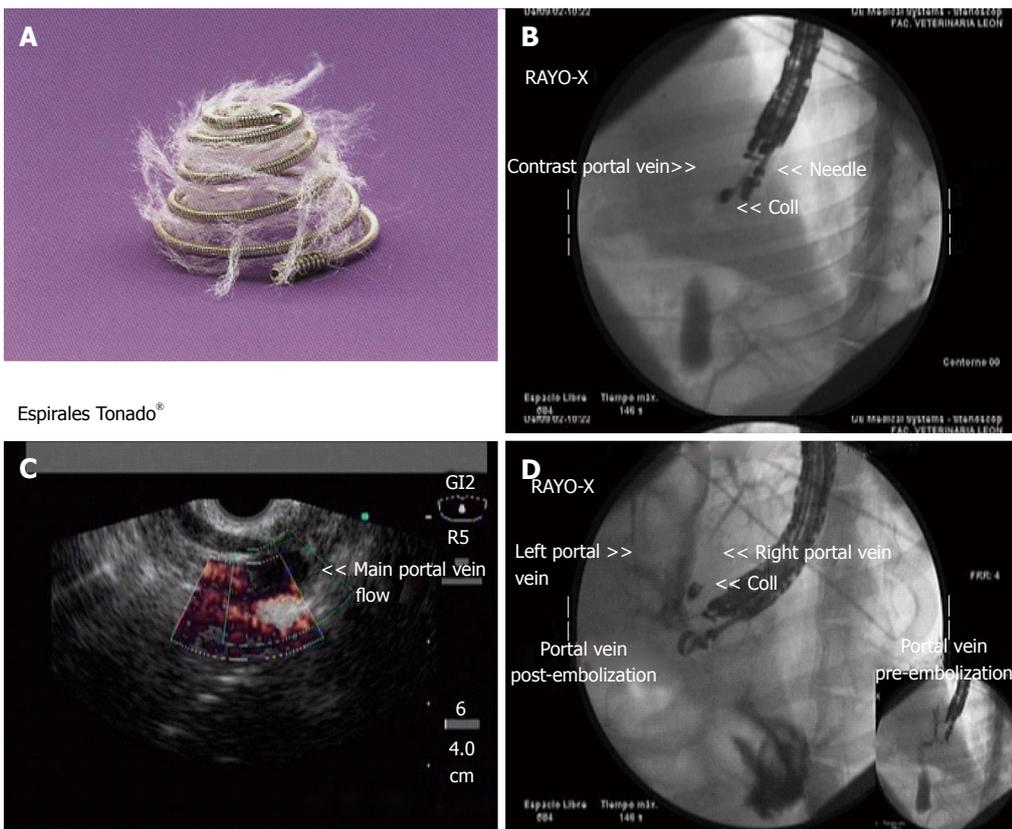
Endoscopic ultrasound-guided embolization with coils of the right portal vein. A: Image of the microcoil used in the experiment that is amenable for EUS-guided delivery^[26]; B: The distal end of the echoendoscope is shown, showing the ultrasound transducer, the needle and the coil being deployed; C: EUS image of the right portal vein showing a grey coloured defect within the vessel that represents the coil after deployment; D: After coil deployment, X-ray fluoroscopy showed no filling of the right portal vein territory, with adequate contrast filling of the left portal vein. Images courtesy of Grupo Español de Protocolos en Endoscopia Digestiva.
